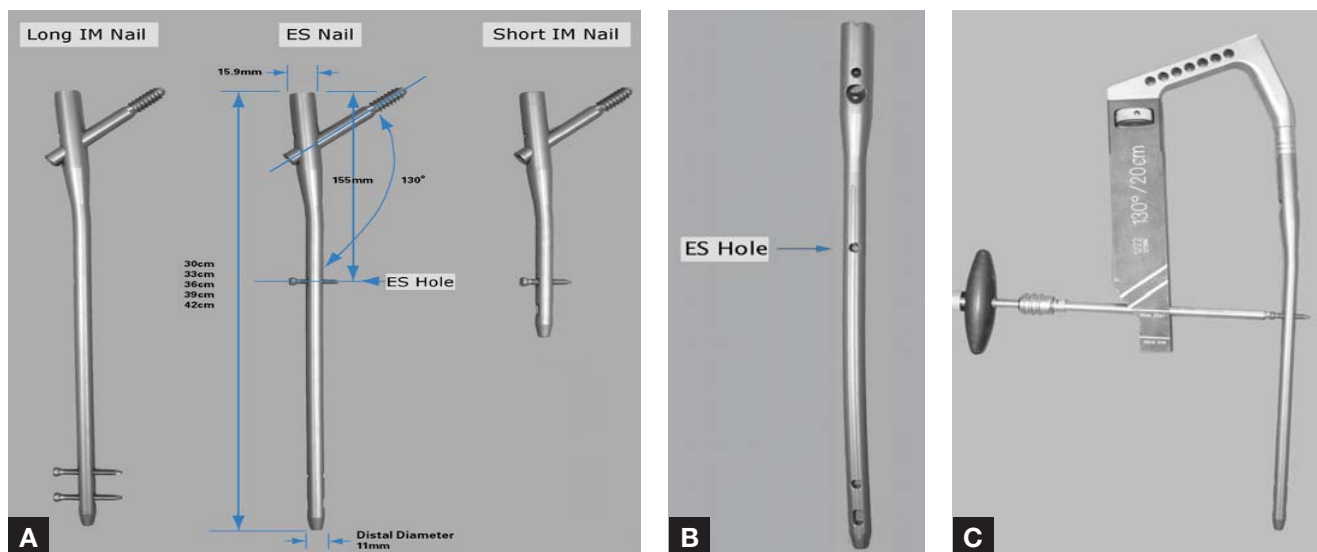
(A) The length of the Extended-Short Nail System (ES nail; Advanced Orthopaedic Solutions, Torrance, California) is the same length as the corresponding standard long intramedullary nail, and the “ES hole” is at the same distance (155 mm) from the proximal tip of the nail as a standard short intramedullary nail. (B) Lateral radiograph of ES nail demonstrating various screw holes and slight anterior bow. (C) ES targeting module locking at ES hole.
